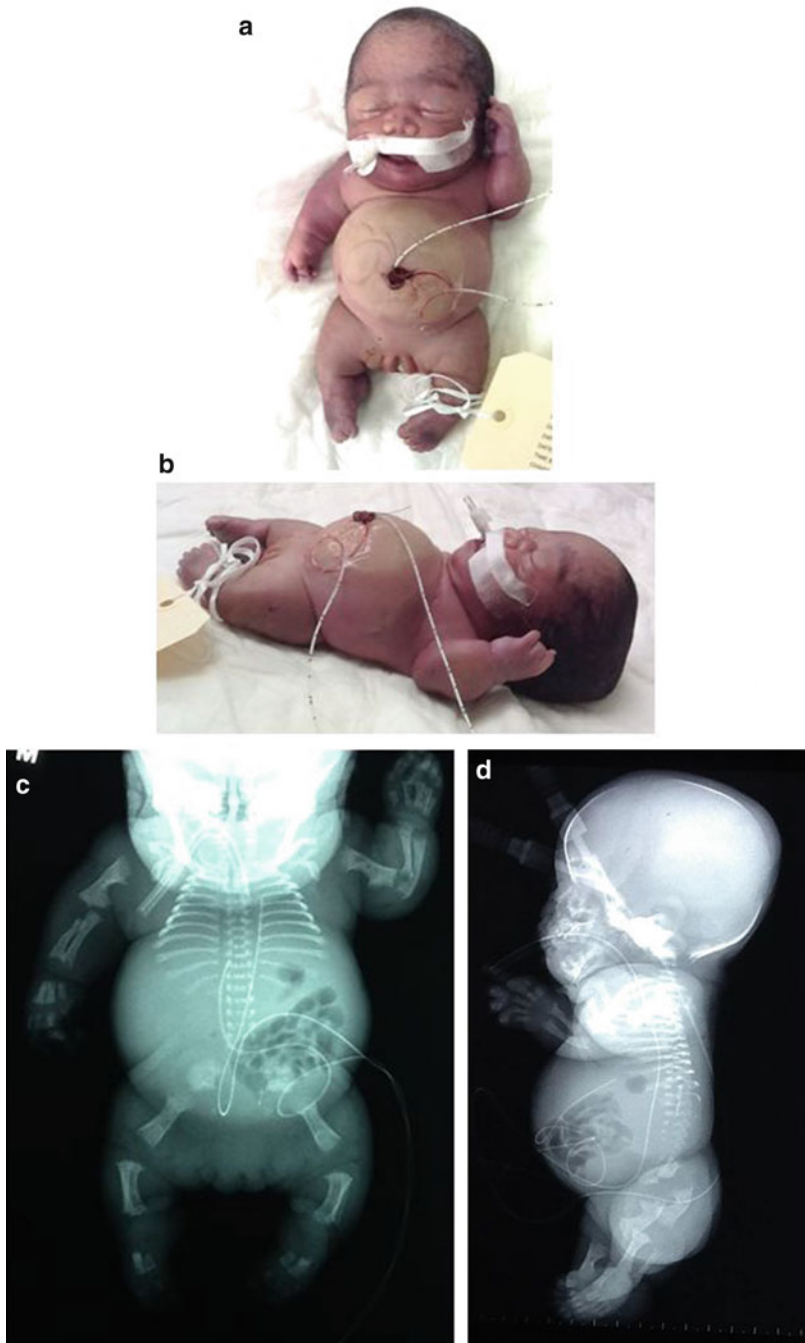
A newborn girl with achondrogenesis type II showing large head, midfacial hypoplasia, short neck, small chest, and short limbs (a). The radiographs show generalized shortening of the long bones of the upper and lower extremities with marked cupping (metaphyseal spurs) at the metaphyseal ends of the bones. This is most evident at the distal ends of the tibia, fibula, radius, and ulna and distal ends of the digits (c, e–h). Radiographs also show
